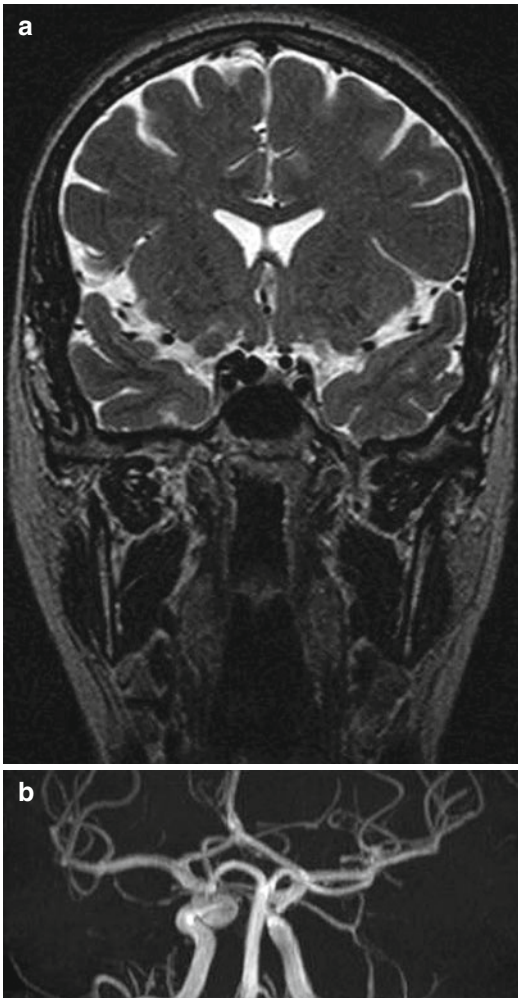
(a) Cranial MRI: a circumscribed area of flow void adjacent to the right ICA correlates with a small CCA extending to the sellar region. (b) Angio-CT: small CCA confirmed
